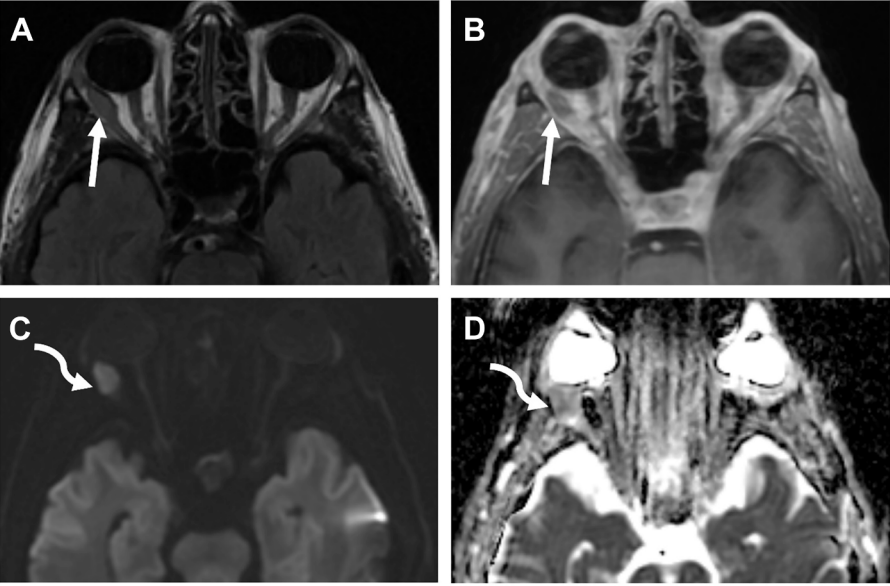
Surveillance brain MRI in patient with history of melanoma. Fluid attenuated inversion recovery (FLAIR) sequence (A) and postcontrast T1-weighted images (B) show subtle asymmetric thickening of right lateral rectus muscle (arrow), which can easily be overlooked. High b-value DWI images (C) and apparent diffusion coefficient map (D) more clearly demonstrate diffusion restricting lesion in right lateral rectus muscle (curved arrow), corroborating suspicion for metastatic deposit. Patient then underwent radiation therapy.
